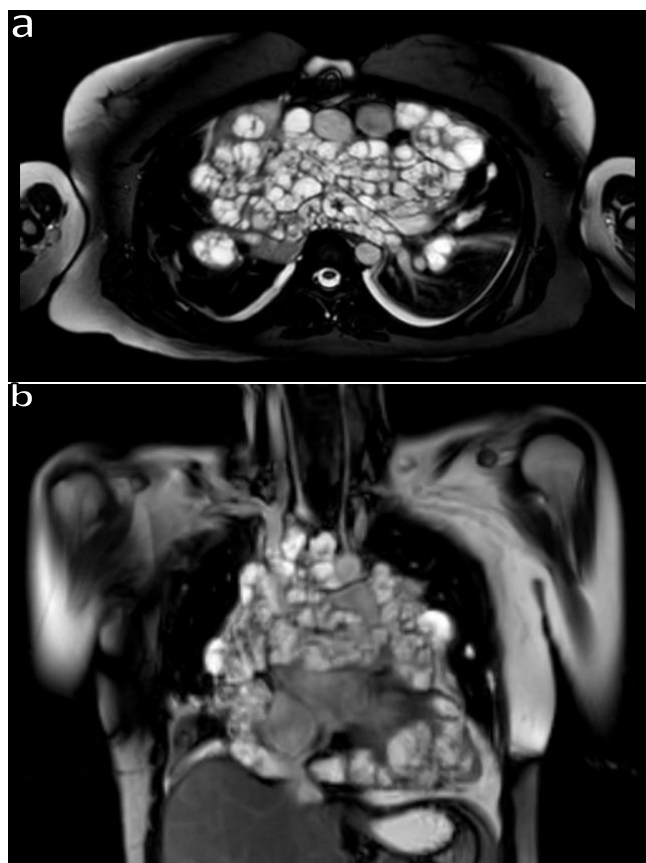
Multiple cystic lesions in the mediastinum on a contrast-enhanced thorax MRI of the case, axial section (a), Multiple cystic lesions in the mediastinum on a contrast-enhanced thorax MRI of the case, coronal section (b)
